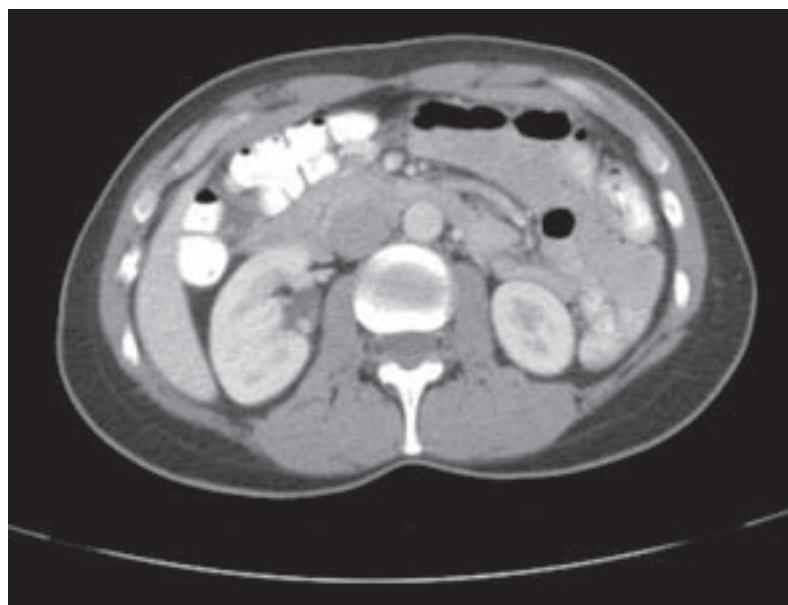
Normal abdominal CT scan.
